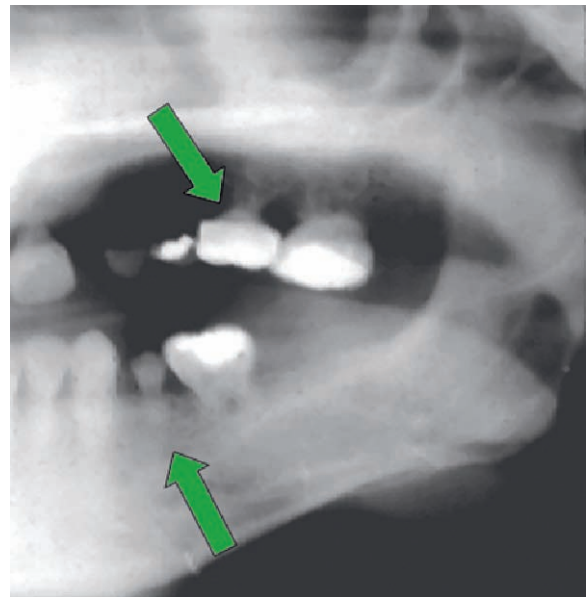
Stunted roots and missing teeth are possible complications of irradiation during childhood (detail from panoramic radiograph)
